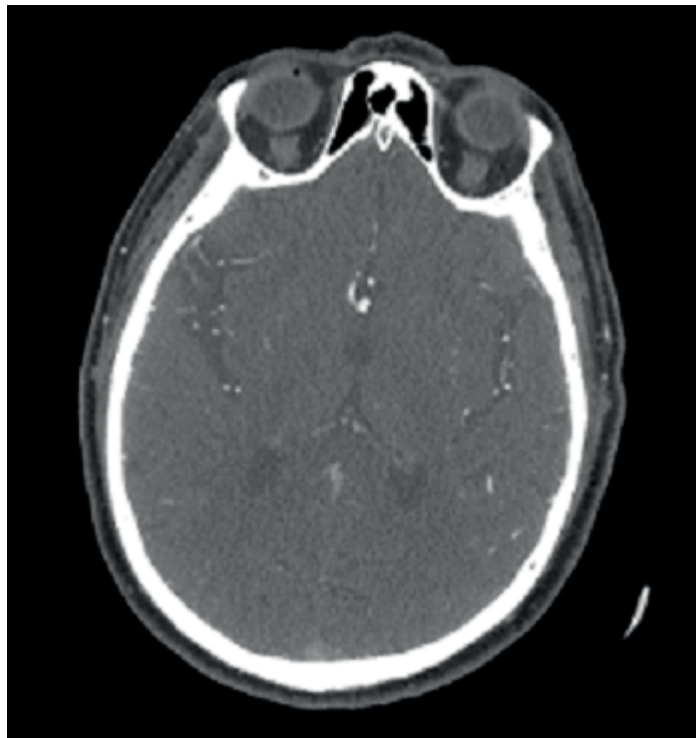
Computed tomographic angiography of the cerebral arteries.
